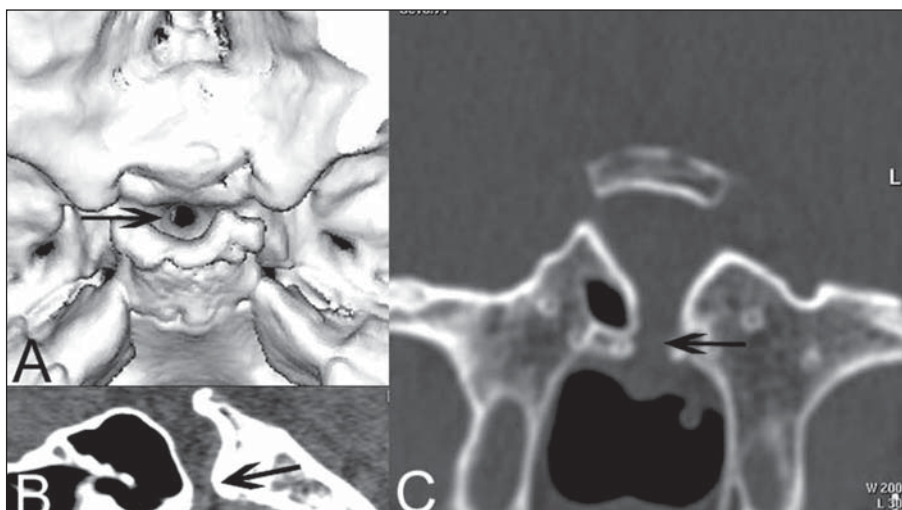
(A) A 3D reconstructed sella turcica CT image showing the main damage of the floor (arrow). (B) CT image reconstruction in the sagittal plane, in soft window showing the damage on the sellar floor and the encephalocele (arrow). (C) Coronal CT image in bone window showing the main flaw on the sellar floor (arrow).
